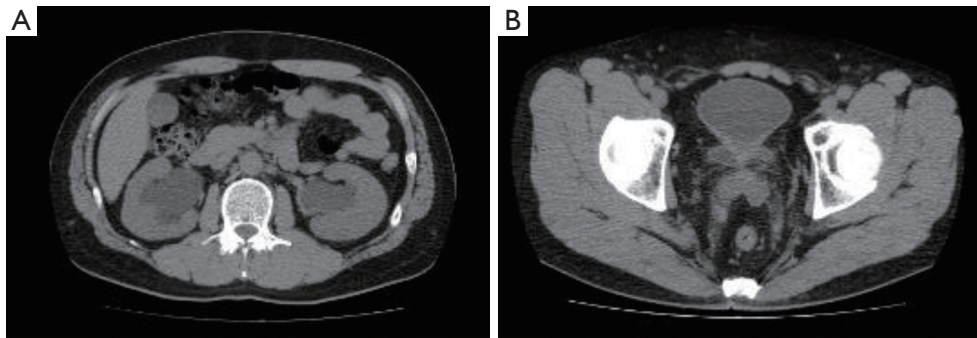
CT images of the patient. (A) CT showing residual bilateral hydronephrosis after repeated transurethral resection of the bladder tumor. (B) Residual inflammation at the trigone of the urinary bladder. CT, computed tomography.
